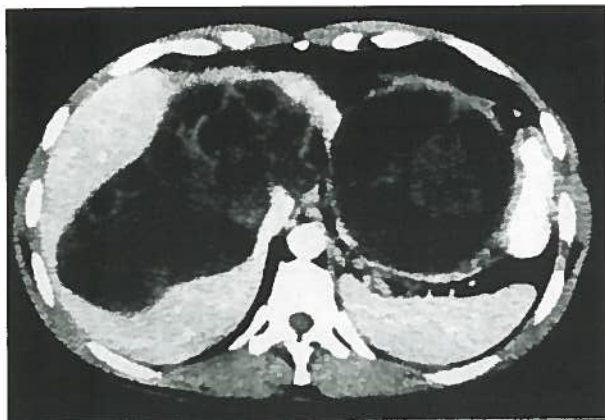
Computed tomographic scan demonstrating a 14 cm, well circumscribed, multi-loculated, predominantly fluid-containing structure with large soft tissue septal components in the left liver lobe overlying the pancreas .
